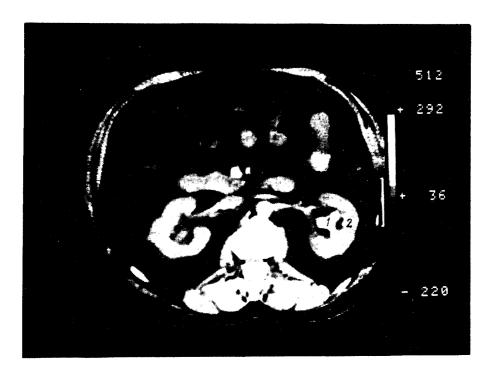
CT scan of a patient with nephrolithiasis.
